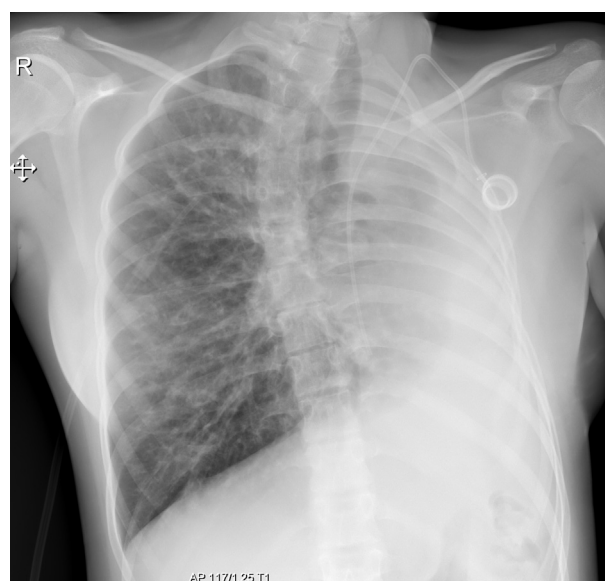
Chest radiograph before lung transplantation.
